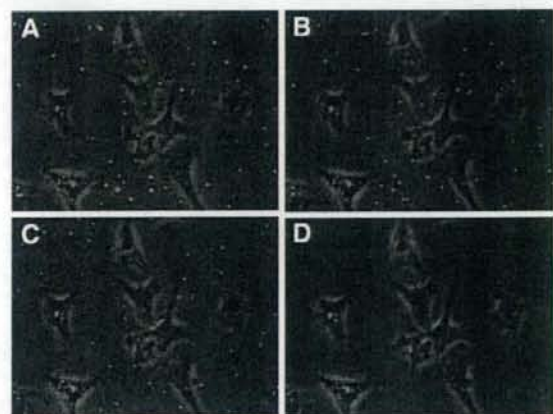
Detachment of an adherent microbubble under high frame rate ultrasound insonation. A, The adherent bubble (arrow) shows no significant change under insonation with MI = 0.21; B, bubble (arrow) drops off and moves away slowly (MI = 0.53); C, most of the microbubbles are compressed under insonation with MI = 0.75; and D, all microbubbles are destroyed at MI = 1.6.
